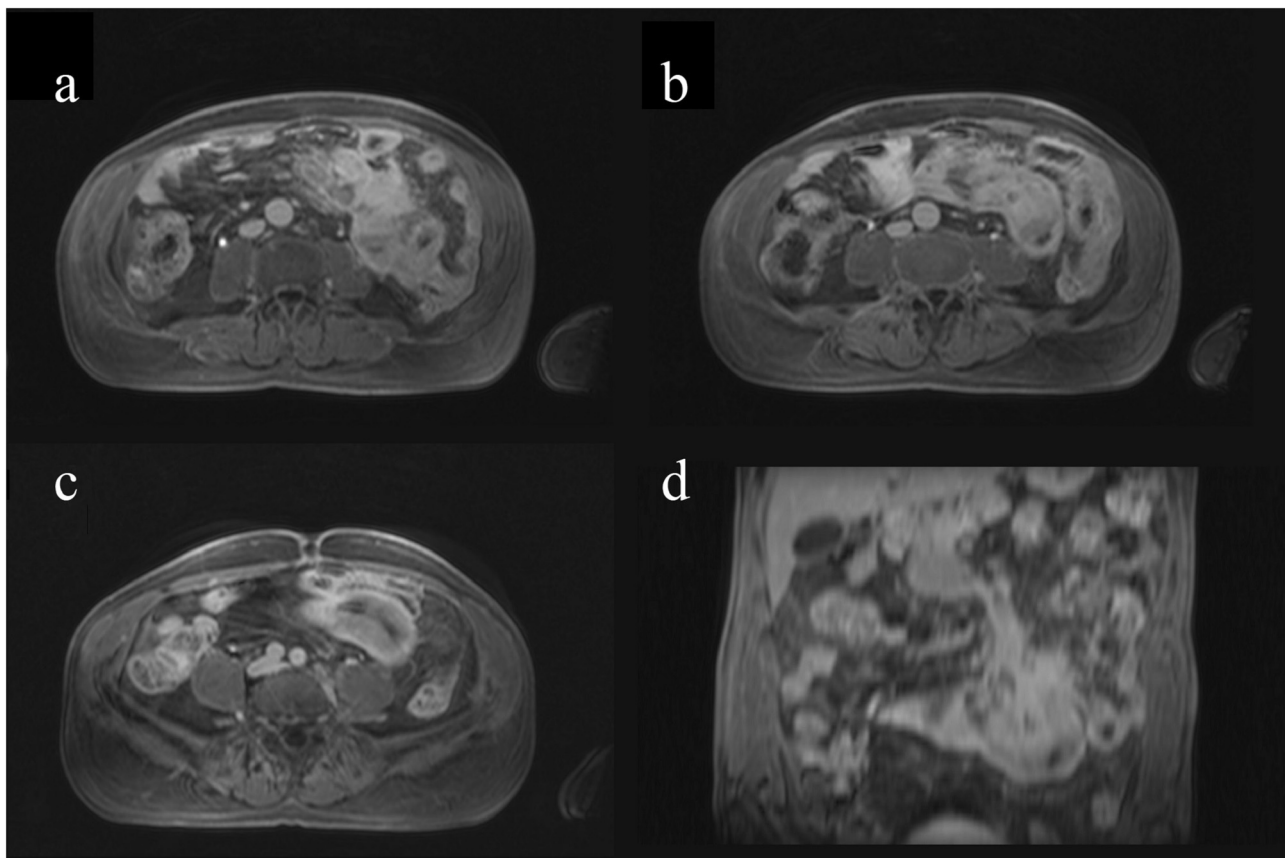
MRI examination after contrast administration. The bulky mass showed few hypointense areas (a), though the enhancement was homogeneous (b,c) with focal widening of the interested small bowel loop; (d) coronal reconstruction.
